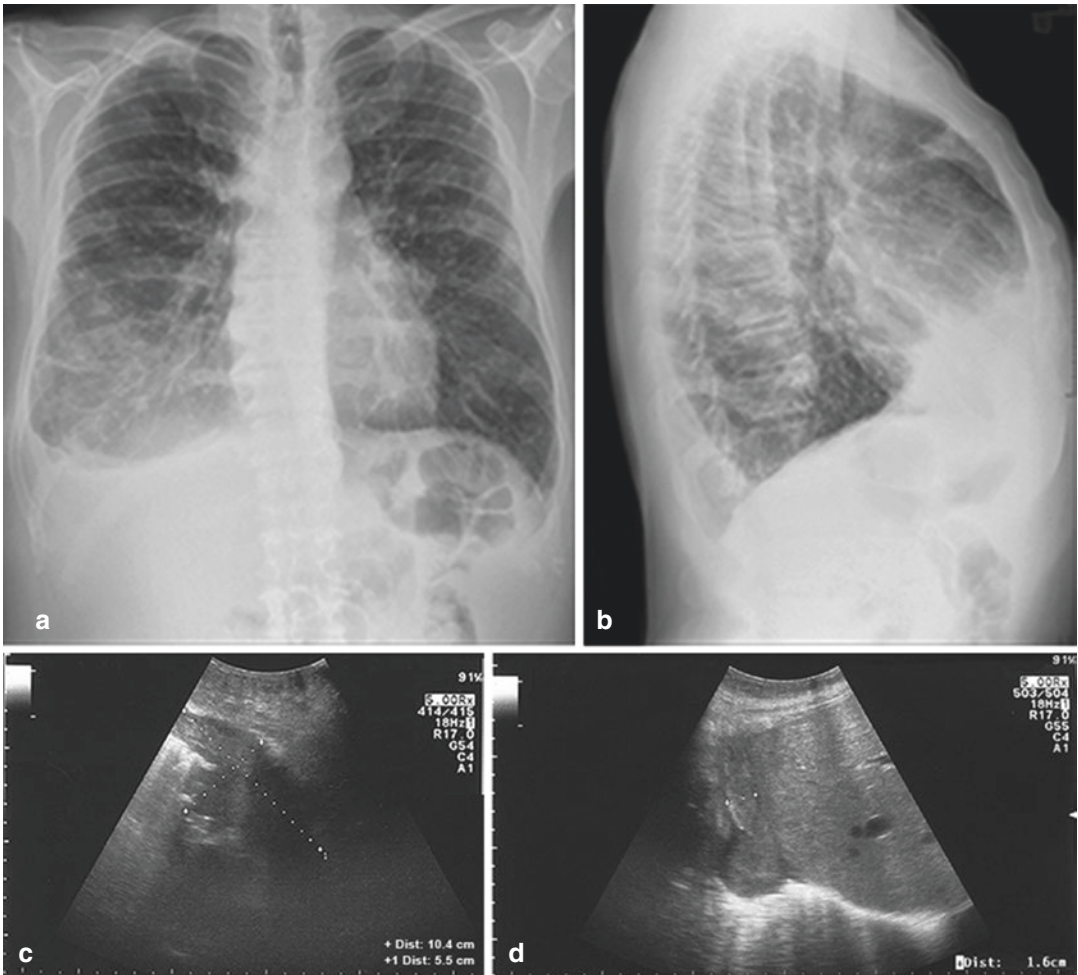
Pulmonary neoplasia infiltrating the chest wall and the diaphragm. X-rays (a, b); TUS with convex probe (c, d) and detail of the chest wall with linear probe (e); CT
